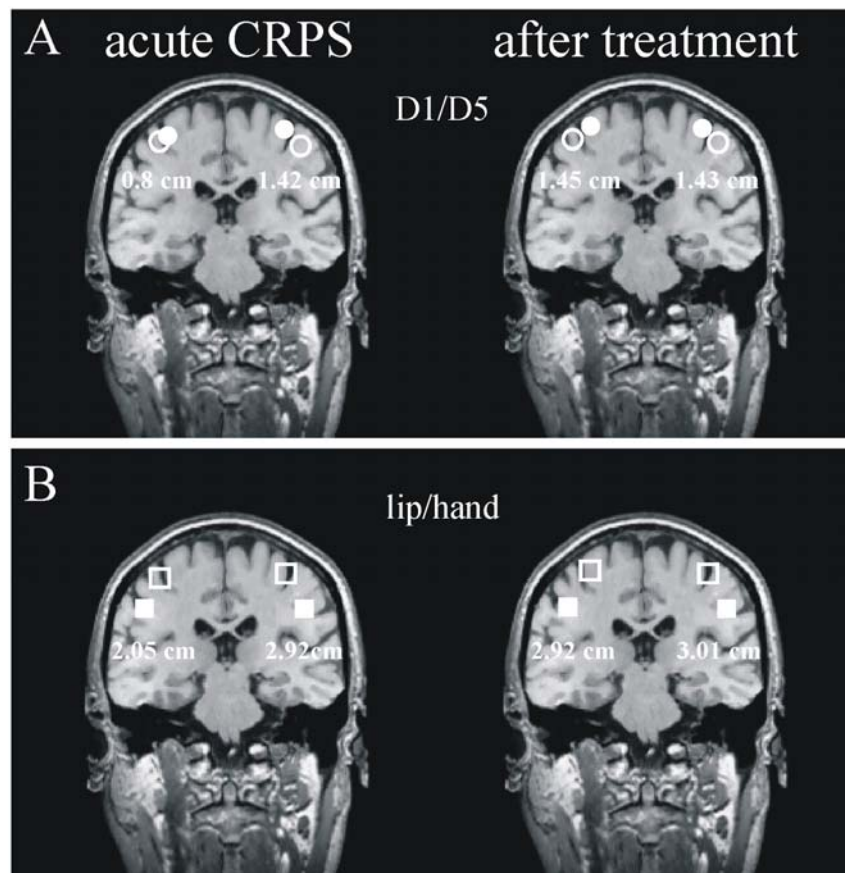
(A) Projection of the equivalent current dipole (ECD) localizations for D1 (filled circle) and D5 (open circle) onto individual MRI slices for one representative patient. There was a reduction of the hand extension from 1.42 cm (unaffected side) to 0.8 cm (CRPS-affected side) during acute CRPS. After the follow up time of 62 months, the distance between D1 and D5 increased to 1.45 cm on the affected side, whereas the corresponding distance on the unaffected side remained unchanged (1.43 cm). (B) Projection of the ECDs for the center of the hand (open squares) and the lower lip (filled squares) onto individual MRI slices. The distance between the center of the hand and the lower lip increased from 2.05 cm to 2.92 cm following therapy on the CRPS-affected side, whereas the respective ECD localizations for the unaffected side remained unchanged (distance hand-lip 2.92 versus 3.01 cm, before and after treatment).
